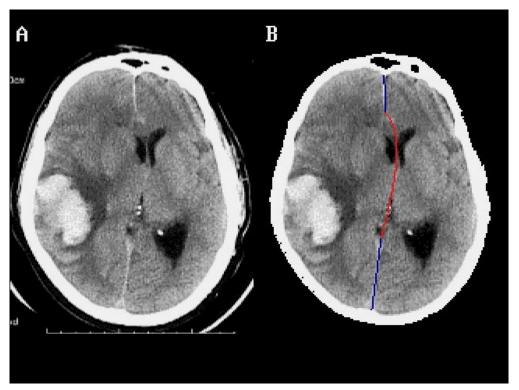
A slice of brain CT from Neurosurgery online database showing intracerebral hemorrhage A: the original image, 312 x 375 pixels, JPEG format; B: the reformatted image (160 x 120 pixels, 16 grey levels) with upper and lower segments of falx (blue) segmented with region growing algorithm and the central segment (red) formed by a Bezier curve (see text); C: the "normal" reference image formed by straightening the midline and expanding the normal (left) hemisphere, then paste the mirror image on the affected (right) side.
